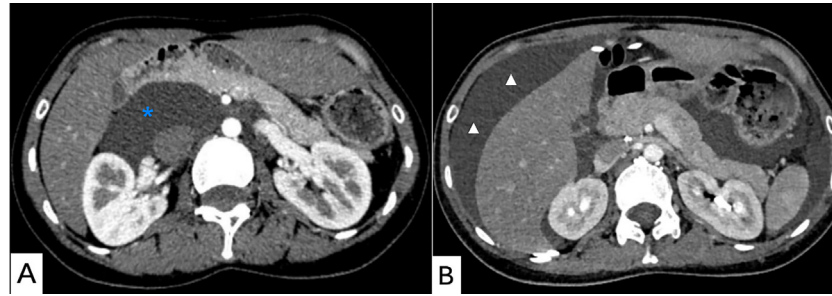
Preoperative retroperitoneal cyst and postoperative ascites. (A) Axial contrast-enhanced abdominal CT at the level of the kidneys demonstrates a large cystic structure within the retroperitoneum, measuring 103×54 mm, with a thin wall and clear fluid (blue asterisk). (B) Postoperative axial contrast-enhanced abdominal CT at the level of the kidneys reveals the presence of ascites (white arrowhead).
